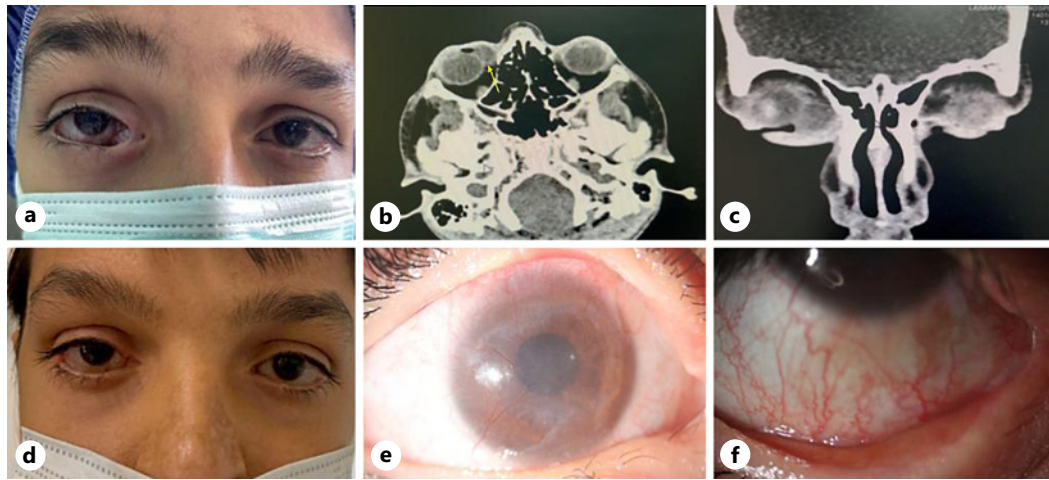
a Preoperative image reveals two conjunctival masses located behind the medial canthus accompanied by ankyloblepharon and inferior fornix. b The axial plane of the computerized tomography (CT) scan shows an isodense lesion located extraconally in the medial portion of the right eye. c The coronal plane of the CT scan shows an isodense well-defined lesion in the inferomedial of the right eye. Postoperative images on month 4 show no sign of conjunctival mass or ankyloblepharon (d), corneal vascularization (e), and an acceptable fornix depth (f).
